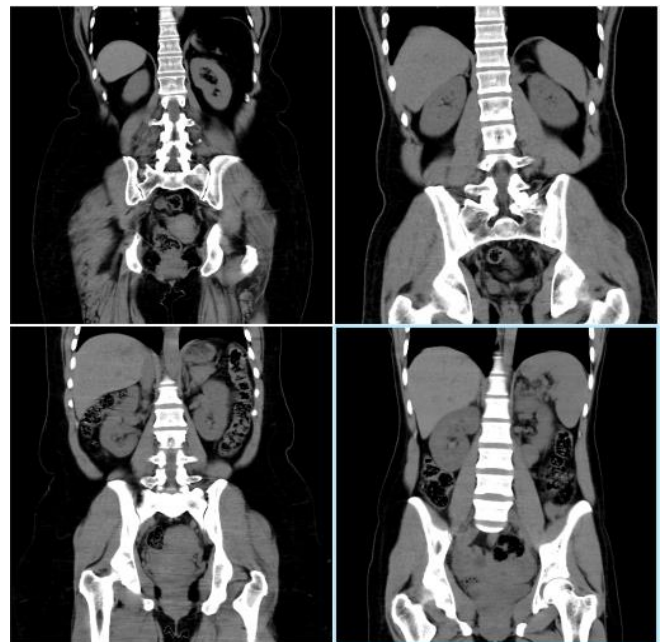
CT scans displaying kidneys with the absence of kidney stones
